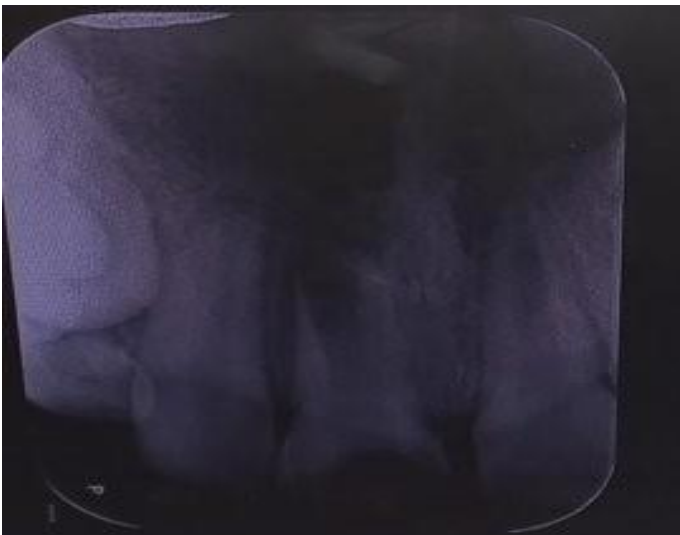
Radiographic image taken before treatment in the 1st session
